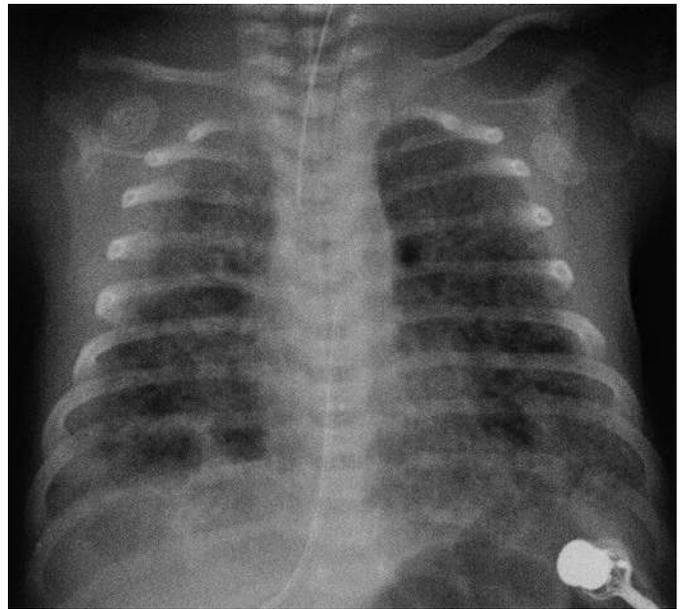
Radiograph of a patient with bronchopulmonary disease (BPD). Anteroposterior radiograph shows areas of scarring, atelectasis, emphysema, and cysts. This film is consistent with severe BPD.
